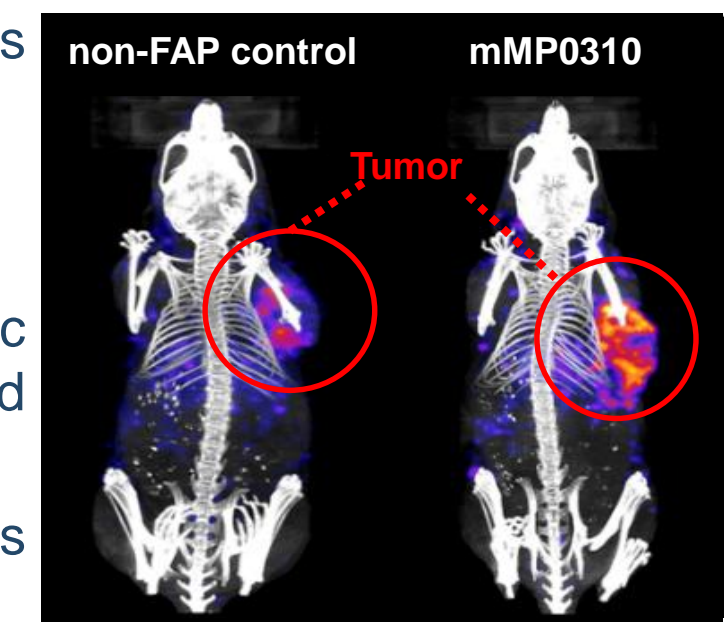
FAP-dependent tumor localization. Whole-body SPECT/CT imaging using ¹¹¹In-labeled DARPin® molecules in the HT-29 model. *Cancer Res.* 2018 78(13 Suppl.):3029.
